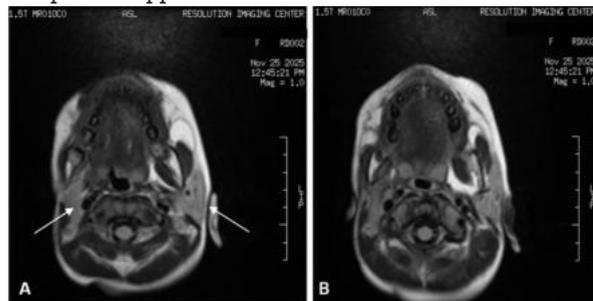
(A) & (B). MRI T2 axial images (A) & (B) showing reduced bulk of right parotid gland (white arrow in image A), right masticator muscles, skin-subcutaneous tissue as compared to opposite side.
